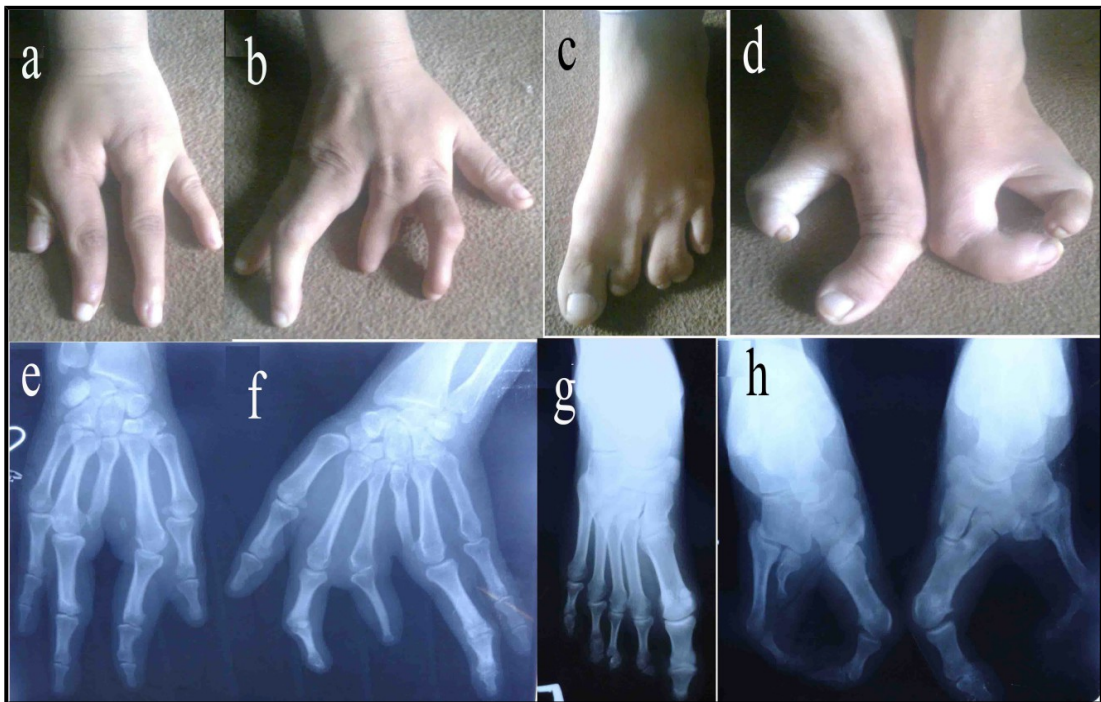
Clinical features of SHFM phenotypes observed in affected members of the family D. Patient (IV-4) showing absence of middle finger, and large proximal phalanx of ring finger in the left hand (a), dysplasia of distal phalanx of index finger and absence of middle phalanx of 3rd middle finger in the right hand (b). Patient (IV-3) showing pre-axial syndactyly of toe 1–2 and post-axial syndactyly of toe 3–4 in patient (c). Patient IV-4 showing a classical cleft foot deformity (d). Radiographic features of left hand of patient IV-4 showing radial ray malformation including hypoplasia of 1st metacarpal, absent middle finger (e), and right hand showing polydactyly, absent phalanx, radial ray hypoplasia (f). Left foot of patient IV-3 showing accessory sesamoid of hallux (g). Right foot of patient IV-4 showing claw foot, hallux valgus, claw toe deformity, basal syndactyly formation, absence of tarsal and metatarsal bones, and prominent 5th metatarsal presenting varus angulation at metatarsophalangeal joint (h). Left foot showing accessory sesamoid of hallux, dysplastic middle and distal phalynx of lesser four toes, and fusion of middle and distal phalynx of the 5th toe.
